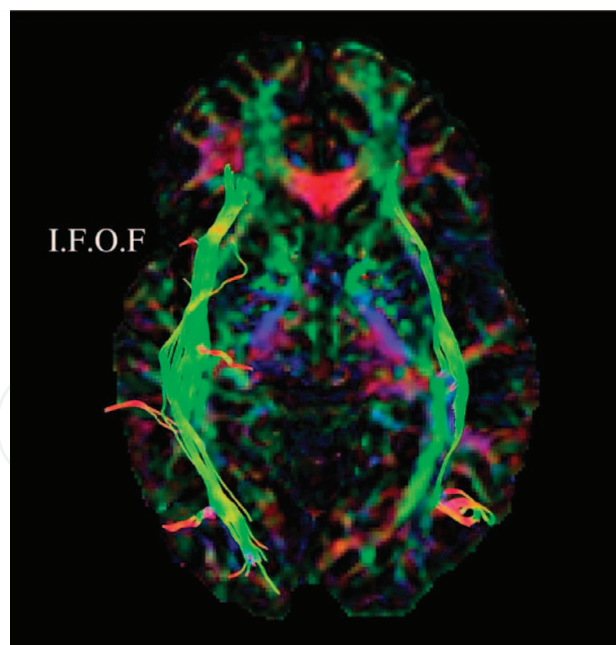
MRI tractography in axial view showing inferior fronto-occipital fasciculus (I.F.O.F) fibers.
